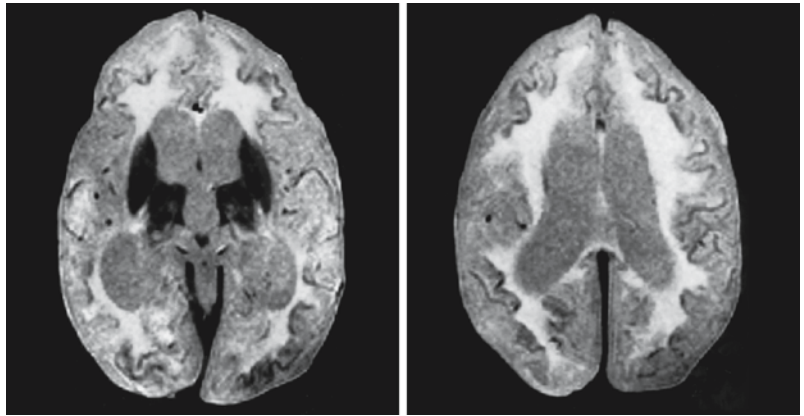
MRI in a 21-month-old girl with INCL shows cerebral atrophy with enlarged ventricles and subarachnoid spaces. The white matter has a higher signal intensity than gray matter in most areas, consistent with disturbed and delayed
